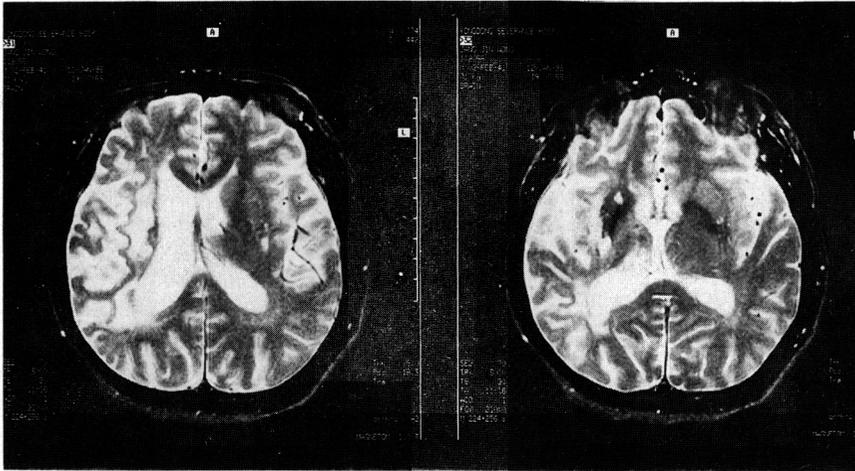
Brain MRI of patient 2 showed an enlarged right frontal horn with high intensity changes involving the caudate nucleus, lentiform nucleus, and cortex (repetition time, 3000 msec; echo time, 80 msec).
